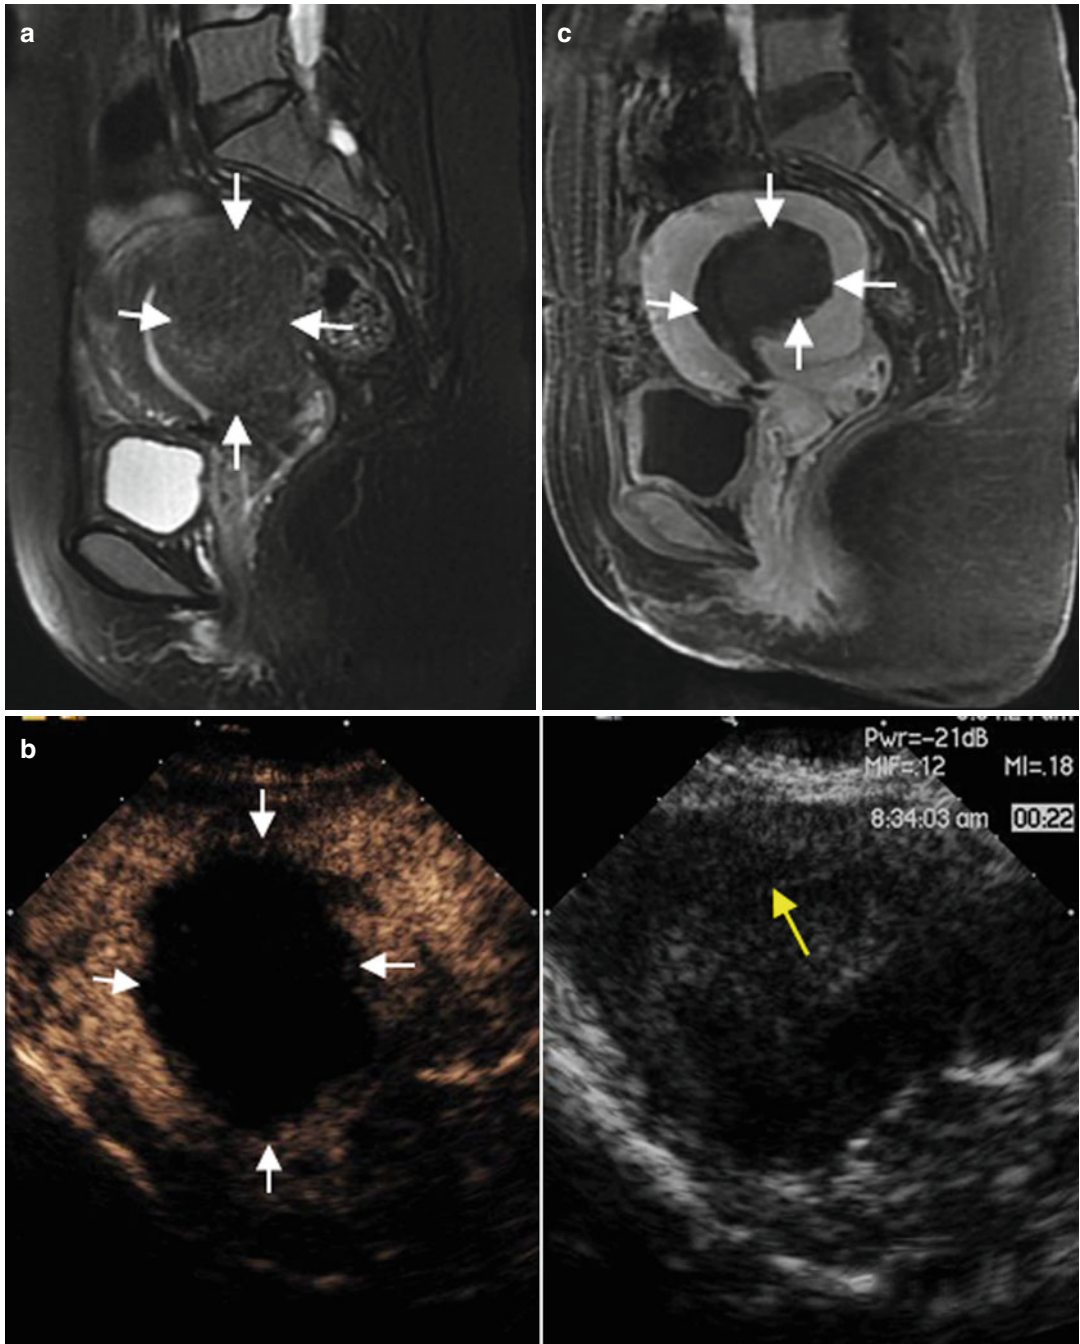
A 35-year-old woman who suffered from adenomyosis with severe dysmenorrhea (VAS 10), hemoglobin 82 g/l. Her uterine size was 8.0 cm×7.3 cm×8.2 cm, and the lesions are mainly located in the posterior wall. (a) MRI (T2WI) before MWA, enlargement of the junctional zone especially in the posterior wall, the area between the *white arrows* is the target area that needs to be
